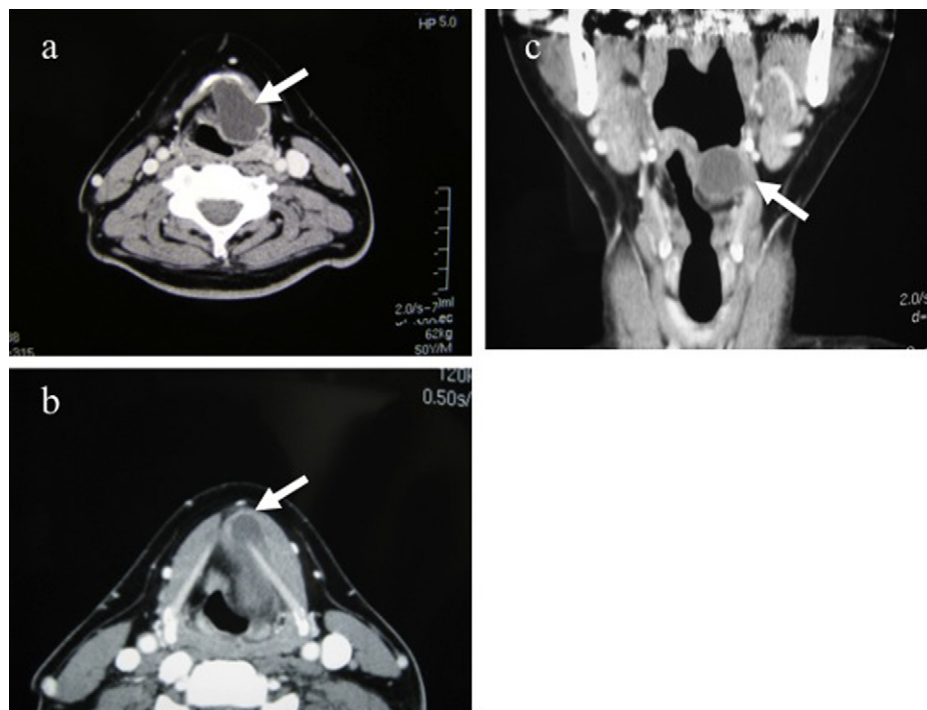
(A) A supraglottic cystic mass, which is extended to the hyoid bone, was detected using computed tomography (arrow). Laryngeal ventricles are intact. The proximity of the cyst and hyoid bone raise the possibility of a thyroglossal duct cyst. (B) The cyst on the upper thyroid notch projected to the pre-epiglottic space (arrow). The cyst was covered by strap muscles. (C) The bottom of cyst was not close to the ventricle in the coronal image (arrow).
